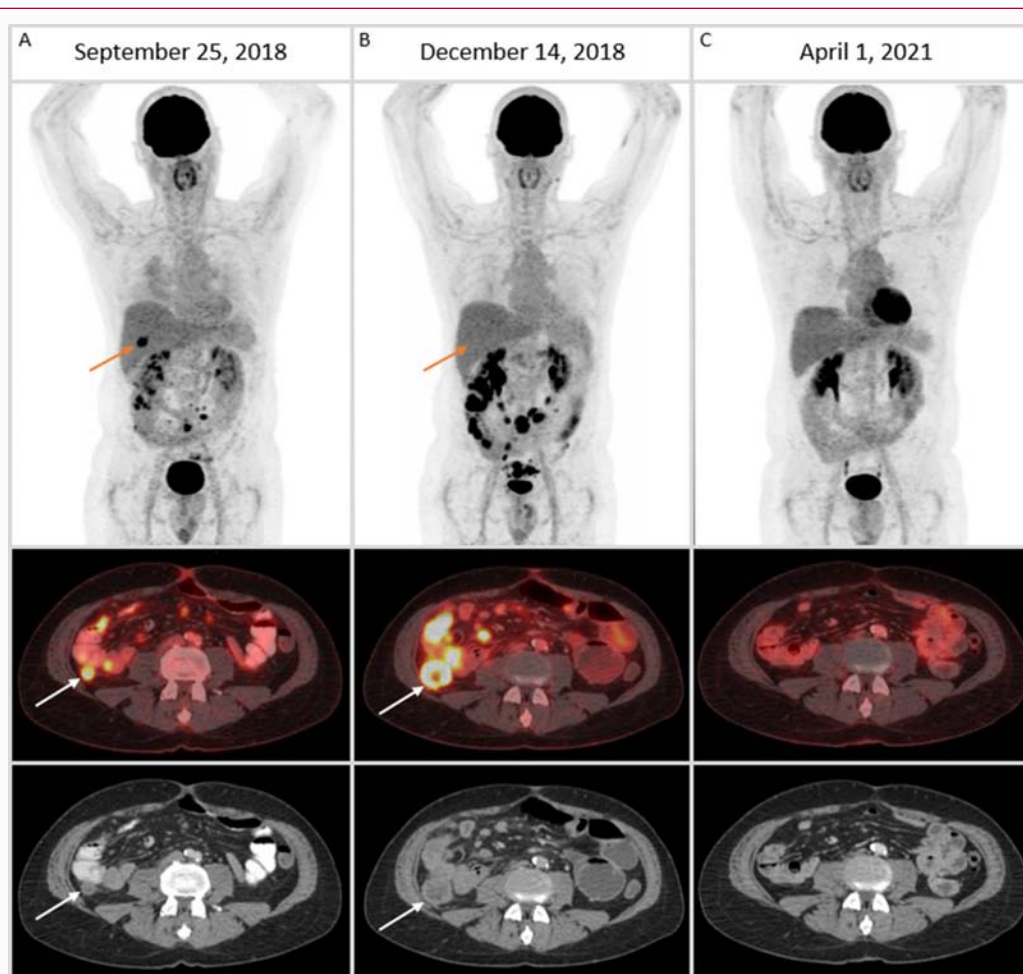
PET-CT demonstrating hyper- or pseudoprogression. The PET-CT at the end of adjuvant chemotherapy (Panel A) demonstrated hypermetabolic hepatic metastases (orange arrow on maximum intensity projection – top image) and one of several hypermetabolic peritoneal masses measuring 1.9 cm, SUVmax 7.1 (white arrow on PET-CT fusion – middle image and CT at same level – bottom image). After three doses of pembrolizumab and clinical signs of progression the PET-CT (Panel B) revealed metabolic and morphologic progression of peritoneal carcinomatosis with the reference mass measuring 3.9 cm, SUVmax 11.3 (white arrow on middle and bottom image) in contrast to metabolic regression of hepatic metastases (orange arrow on maximum intensity projection - top image). After two courses of a second line palliative therapy with FOLFIRI there was near complete remission with minor morphologic residuals in February 2019. The patient remained without hypermetabolic activity as demonstrated on the PET-CT in April 2021 (Panel C).
